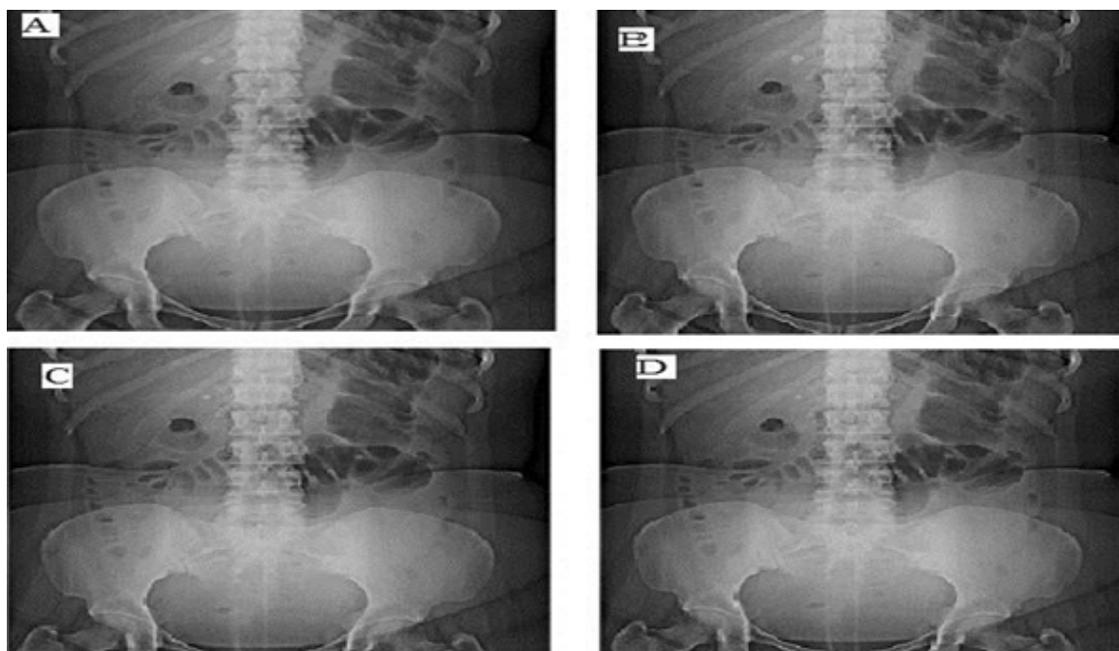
9. X-Ray of formulation H4 after time interval (A) 1 hr; (B) 2 hrs; (C) 4 hrs; (D) 6 hrs
